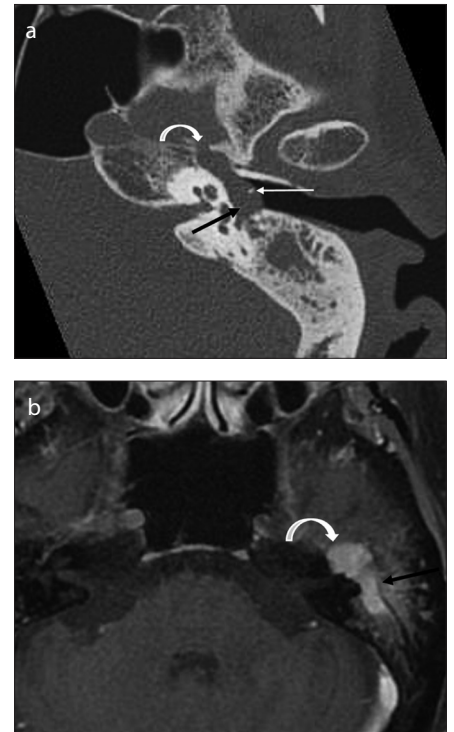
a, b. Axial HRCT (a) and postcontrast axial T1-weighted images (b) of left temporal bone through the IAC show fusiform-shaped FNS causing smooth erosion of the tympanic segment of FN, extending in the middle ear cavity (a and b, black arrow) and displacing the ossicle laterally (a, thin white arrow). It also causes smooth expansion of GG and the facial hiatus (a and b, white curved arrow).
